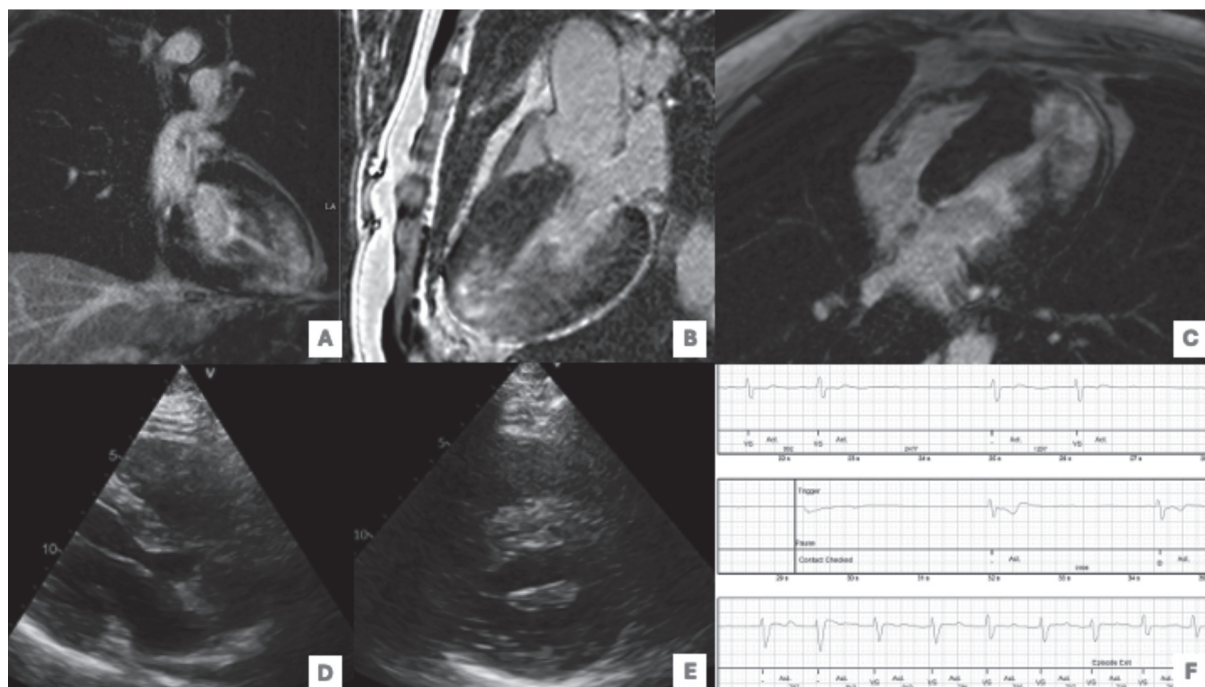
A-C Cardiac MRI imaging in 2-chamber (A), 3-chamber (B) and 4-chamber (C) view with extensive LGE. D-E Transthoracic echocardiography showing evident LV hypertrophy. F Report from the AVB episode registered by the loop recorder
